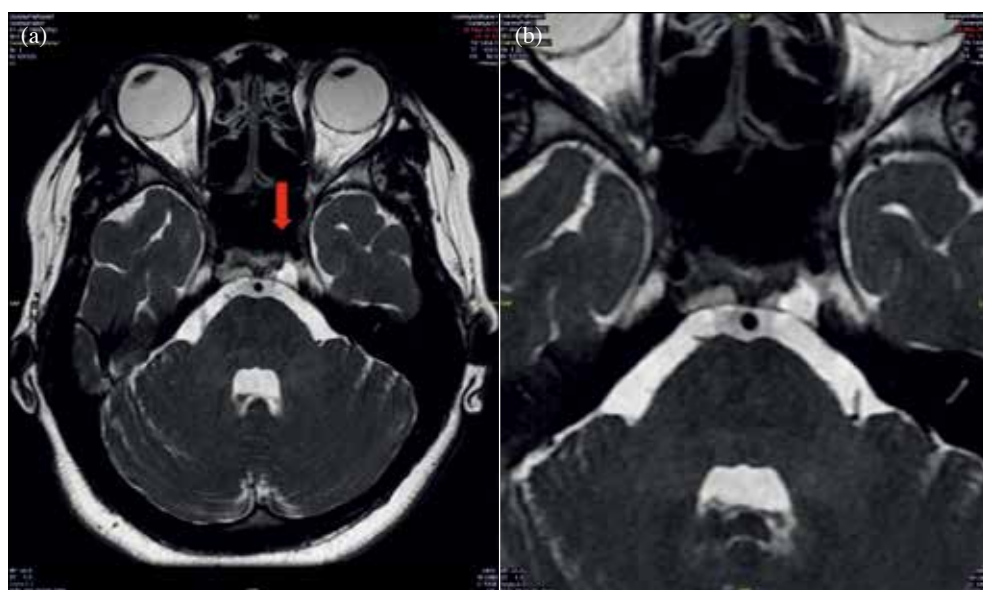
Patient 2: (a) Axial T2-weighted 3D turbo spin-echo sequence magnetic resonance images along the course of abducens nerve revealing a 0.5×0.6 cm non-enhanced mass (arrow) at the left Dorello canal. (b) Post-contrast image does not show the lesion well; the lesion's cystic nature with T1 hypointense signal is similar to the adjacent normal bone marrow.
